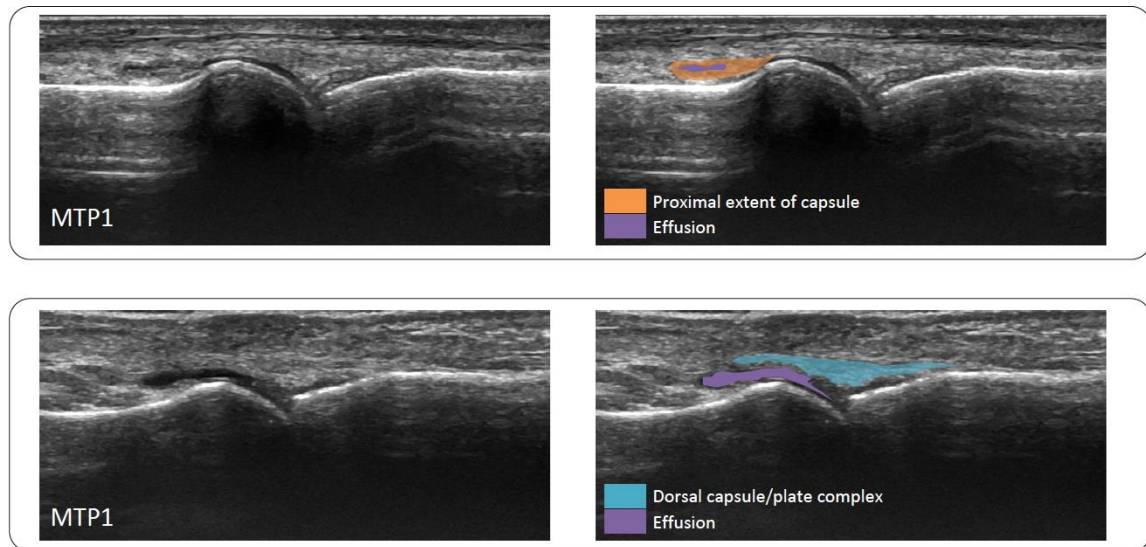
Metatarsophalangeal joint capsule and recess on ultrasound
